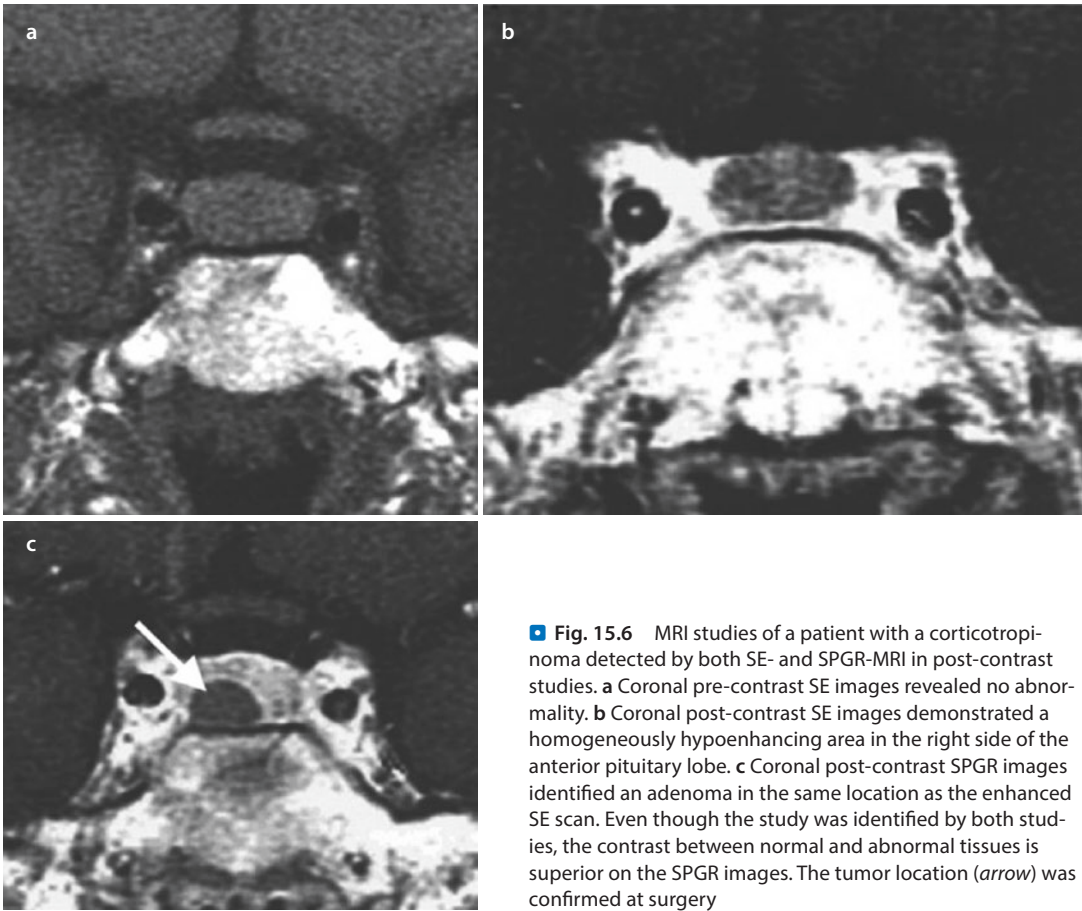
MRI studies of a patient with a corticotropinoma detected by both SE- and SPGR-MRI in post-contrast studies. a Coronal pre-contrast SE images revealed no abnormality. b Coronal post-contrast SE images demonstrated a homogeneously hypoenhancing area in the right side of the anterior pituitary lobe. c Coronal post-contrast SPGR images identified an adenoma in the same location as the enhanced SE scan. Even though the study was identified by both studies, the contrast between normal and abnormal tissues is superior on the SPGR images. The tumor location (*arrow*) was confirmed at surgery
